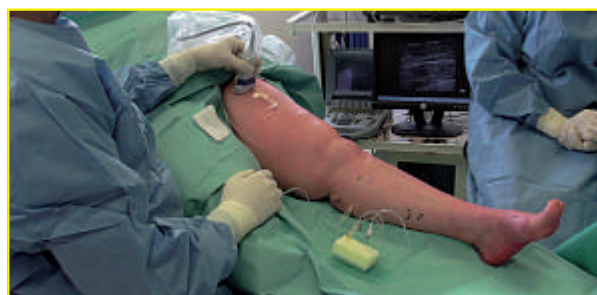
Ultrasound probe and patient installation.
